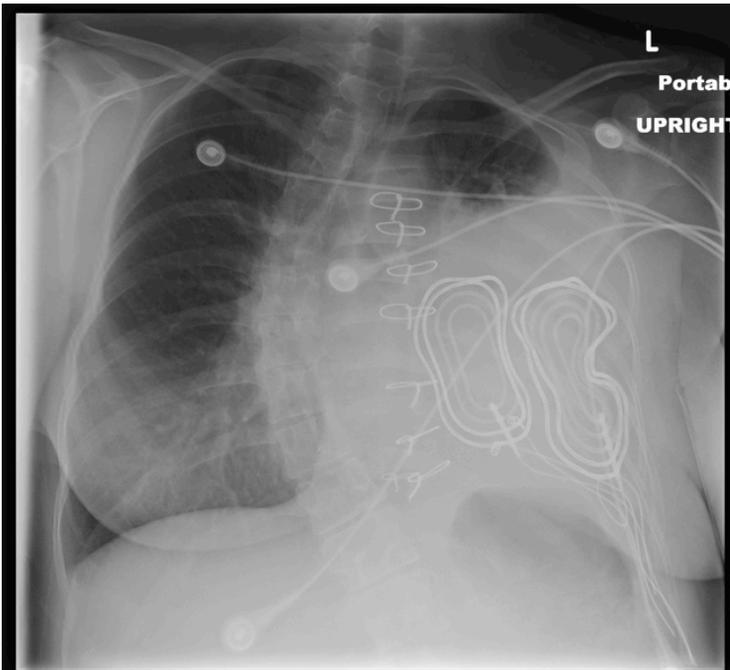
Chest x-ray 12-31-10 Final episode of hemoptysis. The left-sided opacification has progressed over time with complete atelectasis of the left lung.
